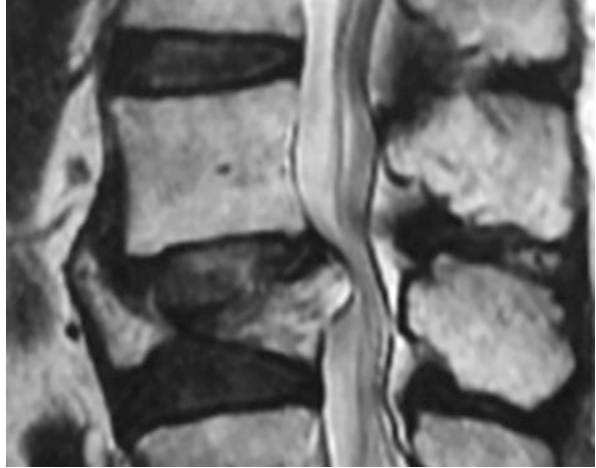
T2-weighted MRI image demonstrating multi-level fractures and overall kyphosis
